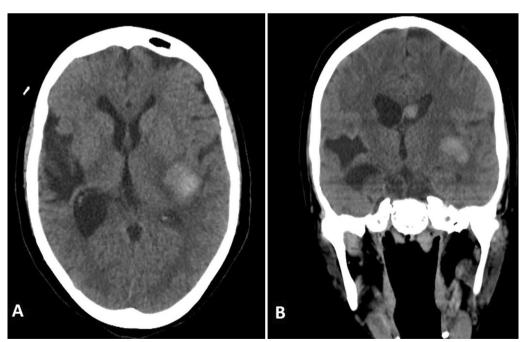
CT scan upon admission to our center, eight days after the hemorrhagic event: A axial, B coronal. CT scan shows the left sided resolving acute temporoparietal hematoma and an area of encephalomalacia on the right temporoparietal region, corresponding to the old hemorrhagic event and causing dilatation of the adjacent temporal horn
